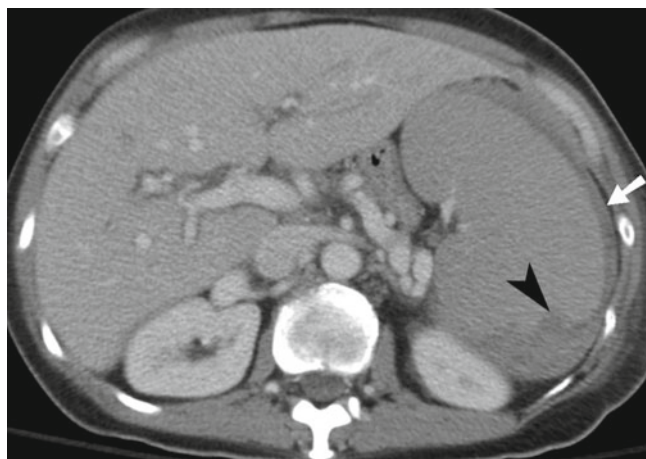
Splenic laceration. Contrast-enhanced CT shows subcapsular hematoma (*arrow*) and intraparenchymal laceration (*arrowhead*) with hematoma
